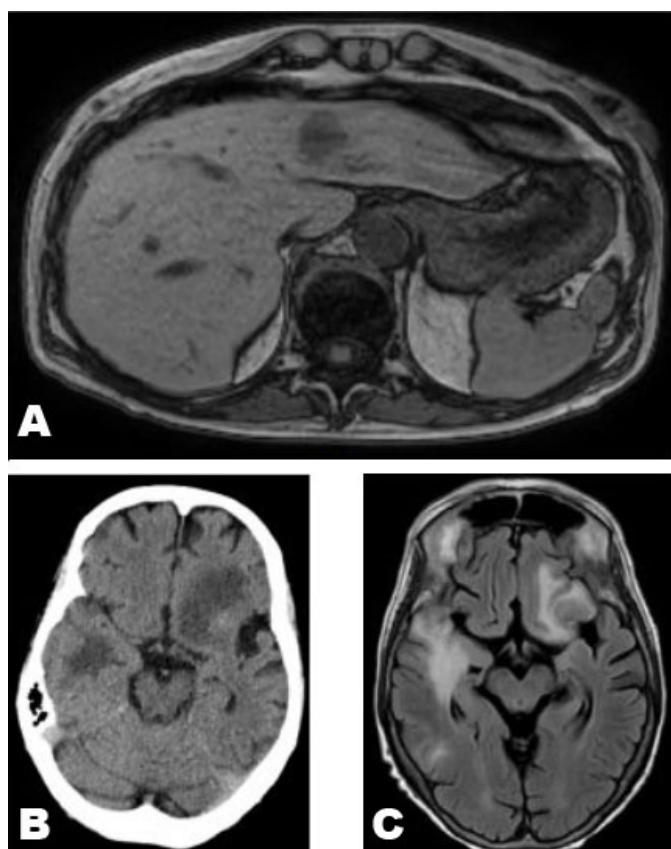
Initial imaging findings. (A) MRI abdomen showing liver lesions concerning for metastatic disease. (B) CT head showing hypoattenuated areas in the left frontal and right-parietal lobes. (C) Axial T2-Flair images showing heterogeneously enhancing lesions in the left inferior frontal lobe, right anterior and posterior temporal lobe, and corpus callosum on presentation.
